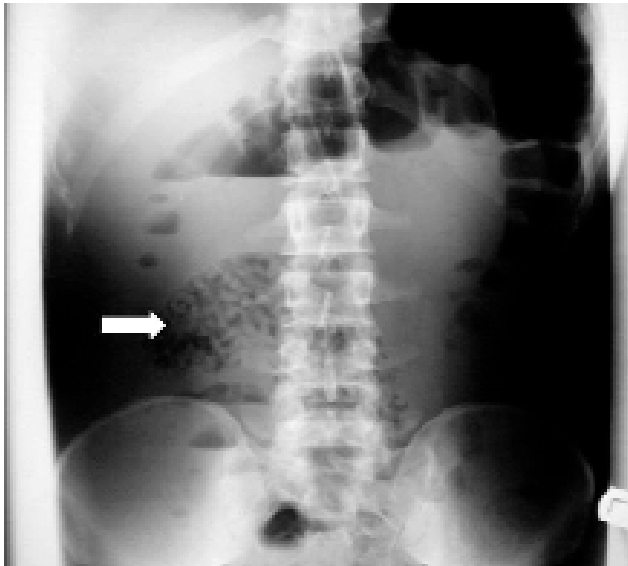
Erect plain abdominal X-ray showing multiple fluid air levels and a classical ball of round worms (white arrow).
